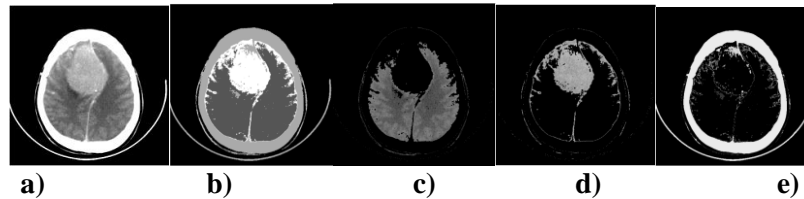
22 EM Segmentation algorithm applied to CT slice.
